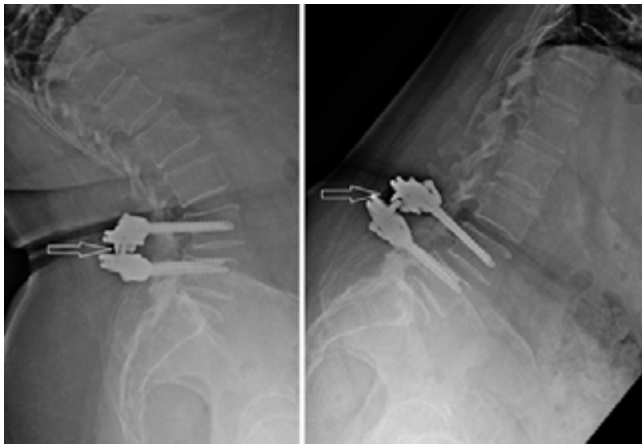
Flexion and extension lateral radiographs obtained after 11 years of follow-up. We can see that there is motion at the L4–5 segment as the articulating core of the TOPS device moves on flexion and extension images (arrows).
